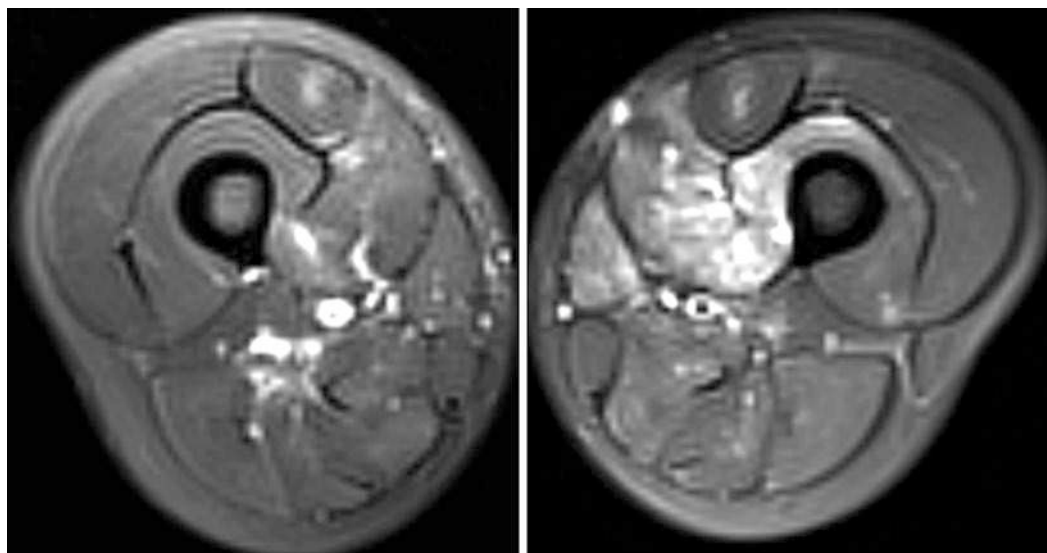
Active polymyositis in a 19-year-old man. There is asymmetric, patchy edema of the muscles of both thighs on this fat-suppressed T2-weighted image. Based on the MR findings, biopsy of the left vastus medialis muscle was performed, leading to the diagnosis
